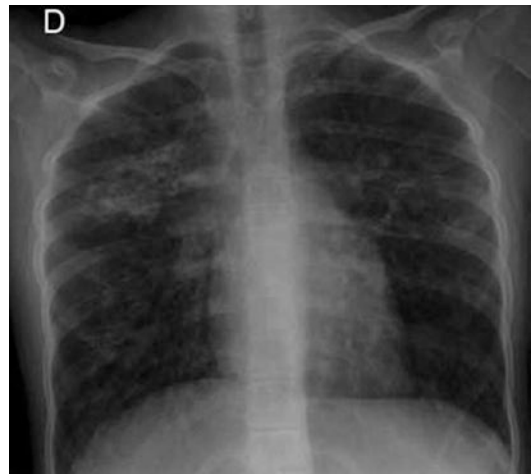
Severe lung disease. Chest X-ray of 14-year-old girl with CF presenting with dyspnea and chronic hypoxemia. Air trapping can be observed along linear and cyst images. Bilateral bronchiectasis, condensation, and bullae at the apex of the right lung
